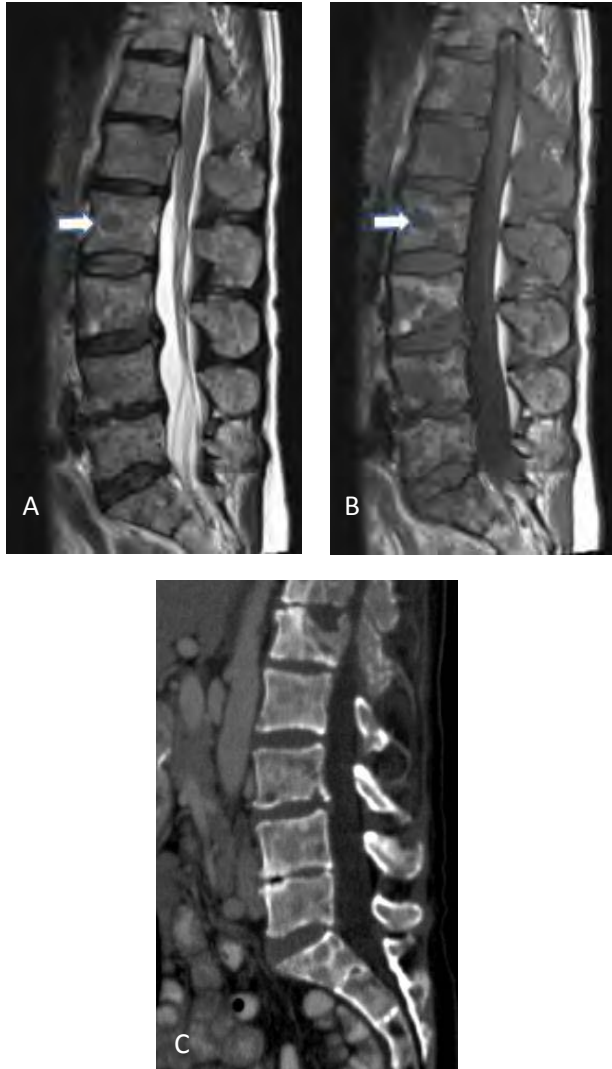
Sagittal T2 (A) and T1 (B) MR images in a patient with metastatic breast cancer demonstrate heterogeneous signal throughout the bone marrow with numerous hypointense lesions. A lesion within the L2 vertebral body demonstrates a halo sign with peripheral rim of increased T2 and T1 signal (arrows). There is a corresponding region of a faint rim sclerosis on CT (C). CT also demonstrates heterogeneous attenuation with foci of sclerosis throughout the spine, as well as a compression deformity at the superior L1 level.
